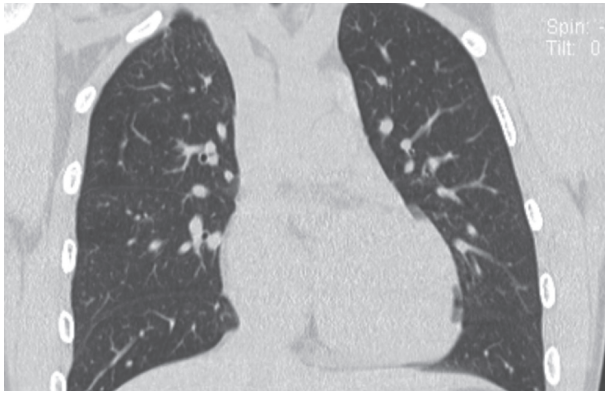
Control computed tomography after three months.
